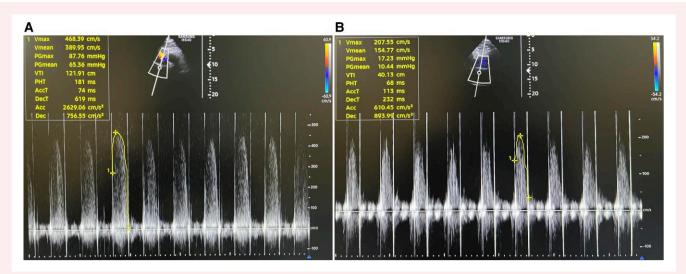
The right parasternal TTE view was required for accurate evaluation of prosthetic aortic valve stenosis severity. There were markedly elevated transvalvular peak (87 mmHg) and mean (65 mmHg) pressure gradients (A). Prosthetic valve peak and mean pressure gradients had decreased to 17 and 10 mmHg, respectively, after the thrombolytic treatment (B).
